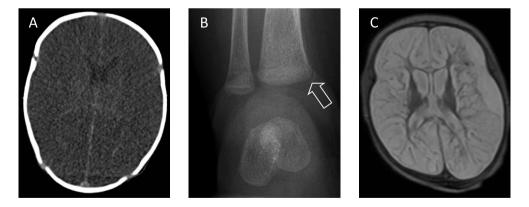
A two-month-old girl admitted because of abusive head trauma. The CT obtained at admission shows an overall decrease in density of brain tissue and a lack of grey-white matter differentiation. This is a sign of severe hypoxia of the brain and has a poor prognosis. Figure 2b. The skeletal survey shows a metaphyseal corner fracture of the distal tibia. This, in combination with the intracranial trauma, is highly indicative of abusive head trauma. Figure 2c. Five weeks after the initial CT scan, the girl has developed extensive diffuse multicystic encephalomalacia.
